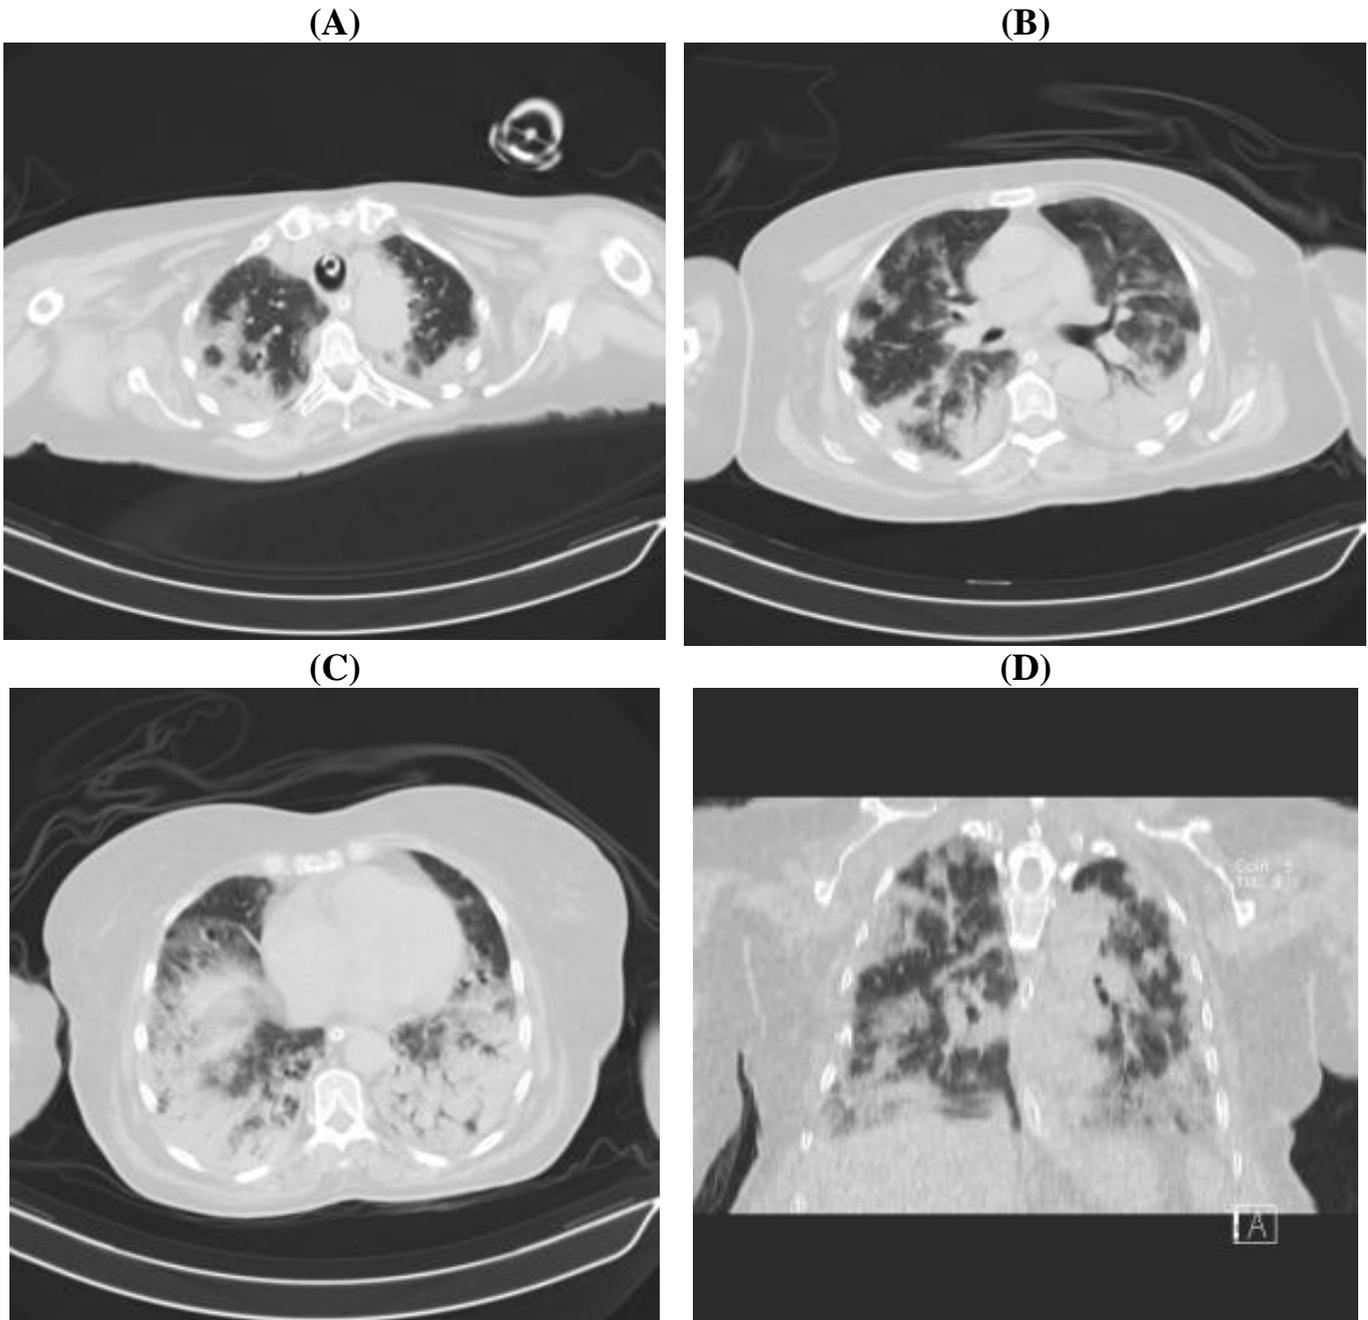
(A, B, C axial and D coronal): Female patient 62 y. Unenhanced chest CT scan shows bilateral and peripheral distribution of ground-glass opacities more dominant in the lower lobes and mounting to consolidation. Endotracheal tube is seen. CT-SS was 21. The patient showed unfavorable course and died.
